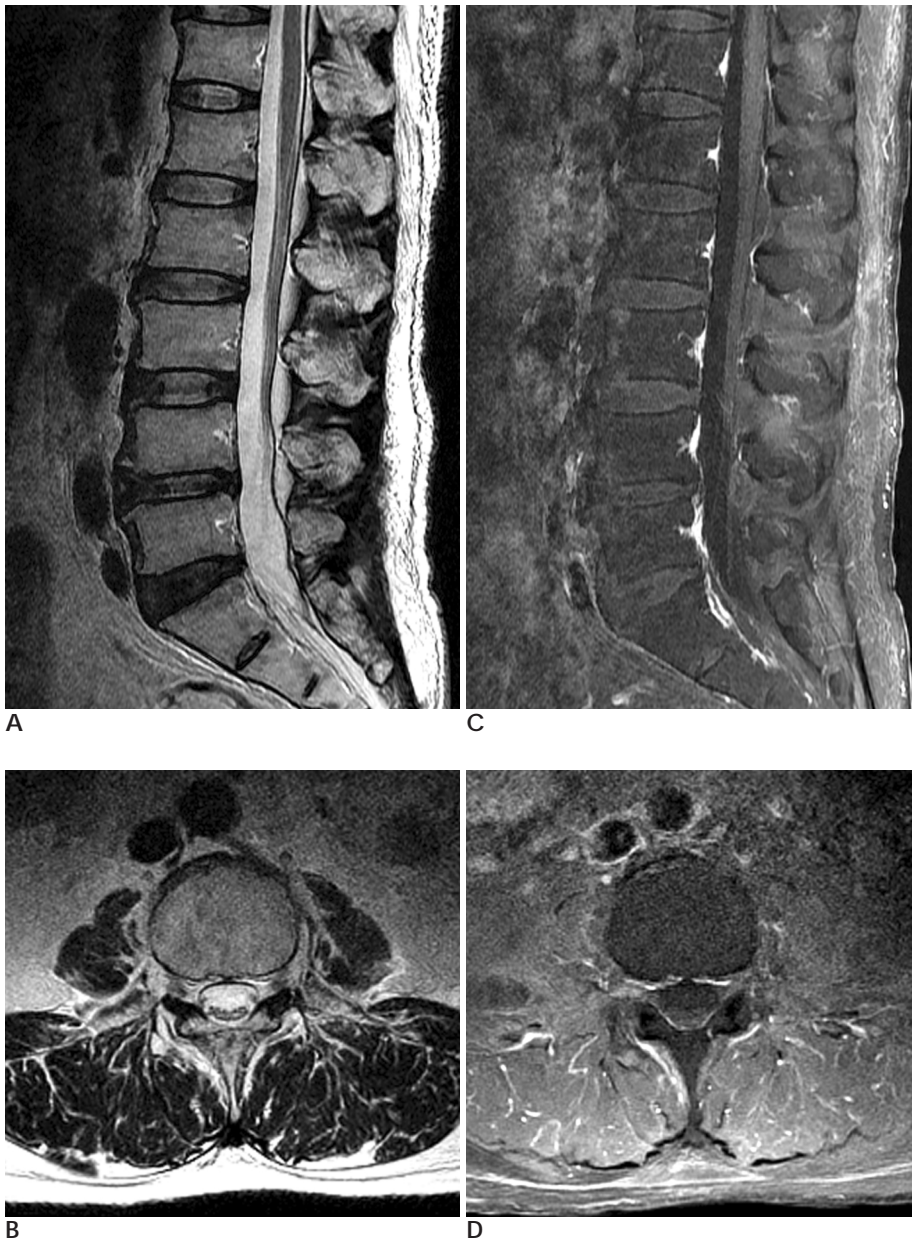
Follow-up MR images after remission.
